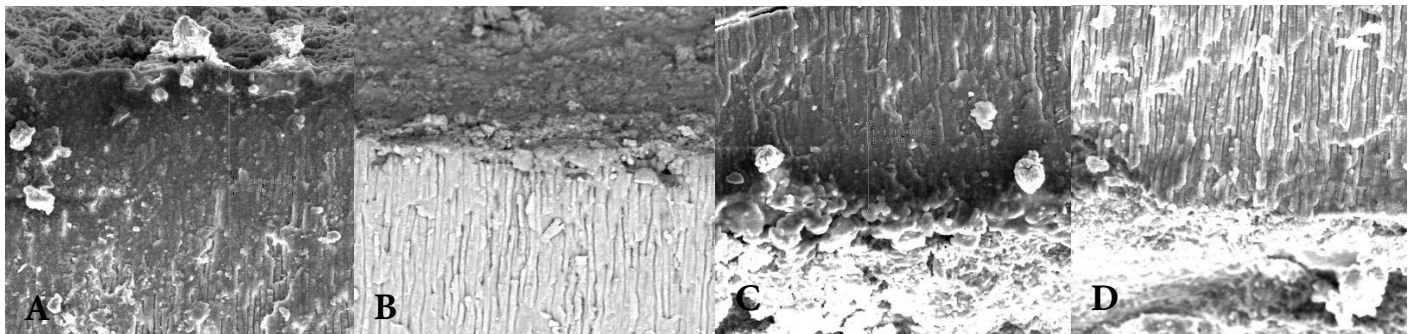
SEM analysis at 1000× magnification for the determination of penetration of bioceramic sealer into the dentinal tubules in the coronal third after agitation with: A) Passive ultrasonic irrigation; B) 30-G needle in a syringe; C) XP-Finisher file; D) Er:YAG laser can be seen.
